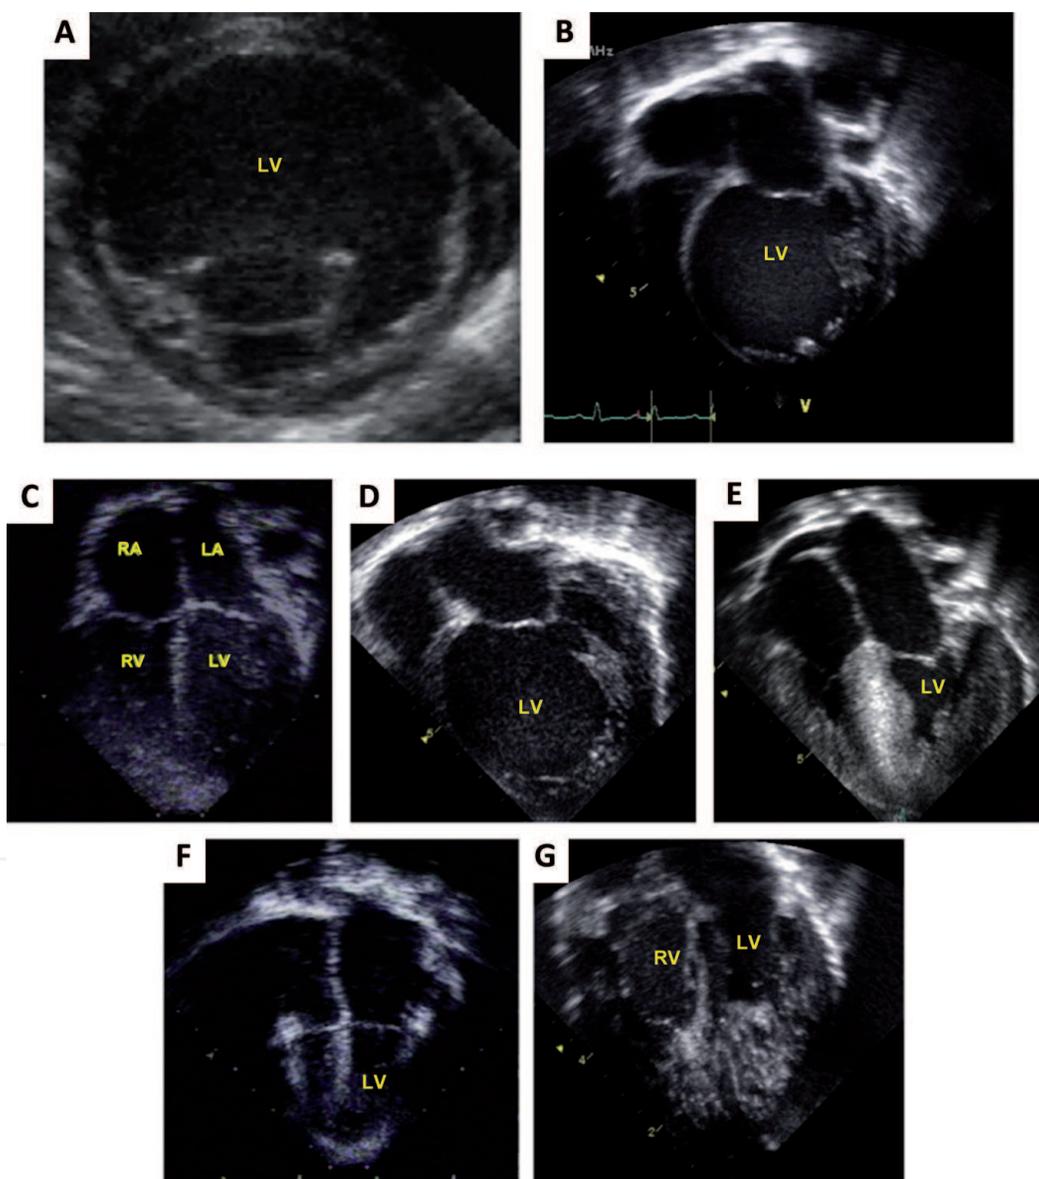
Echocardiographic images of heterogeneous forms of left ventricular noncompaction phenotype. A. Parasternal short-axis view of a dilated form of LVNC with trabeculations noted at the apex. B. An apical 4-chamber view with trabeculations noted at the right side of the image. C-G, Heterogeneous phenotypes associated with LVNC. LVNC with normal LV size, thickness, and function (C), dilated form of LVNC (D), hypertrophic form of LVNC (E), restrictive form of LVNC (F), biventricular LVNC (G). LV, left ventricle; RV, right ventricle; LA, left atrium, RA, right atrium.
